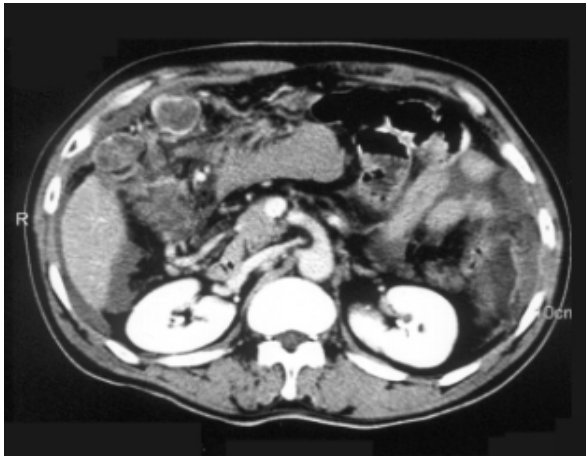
Peritoneal implanted metastatic nodules are detected with hemorrhage on abdominal CT scan(7 months later)
